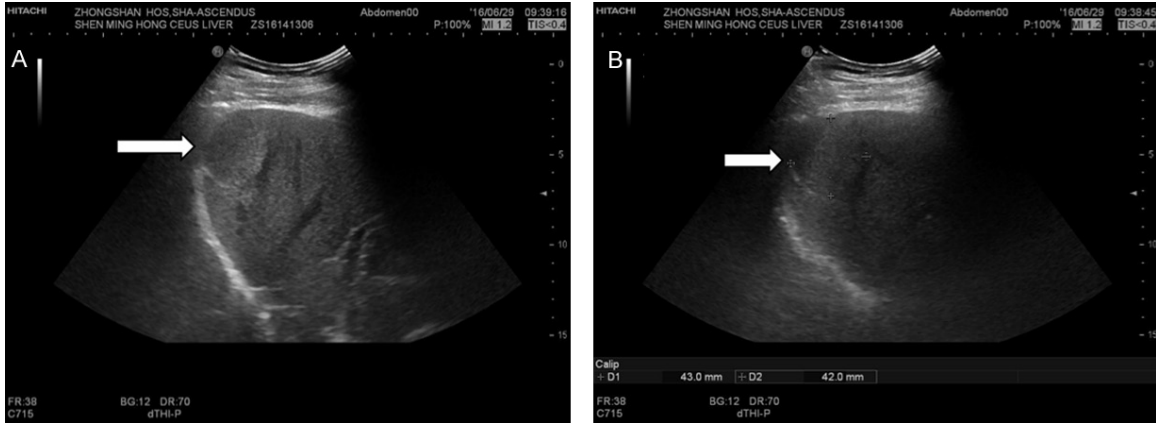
US of the liver. Ultrasound presents a hypoechoic lesion with a rim of hyperechoicity.
